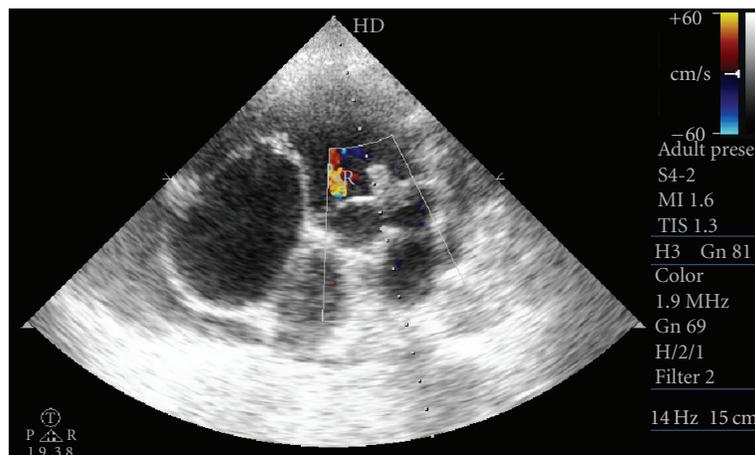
Parasternal SAX view depicting mild aortic regurgitation.
